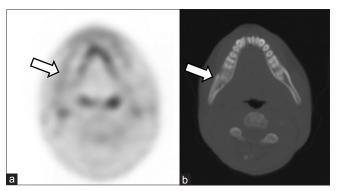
Selected fluorodeoxyglucose positron emission tomography (a) and corresponding computed tomography axial image (b) performed before therapy to assess disease extension shows no abnormal uptake corresponding to the osseous lesion (arrow). The rest of the fl uorodeoxyglucose positron emission tomography scan was unremarkable (not shown)
